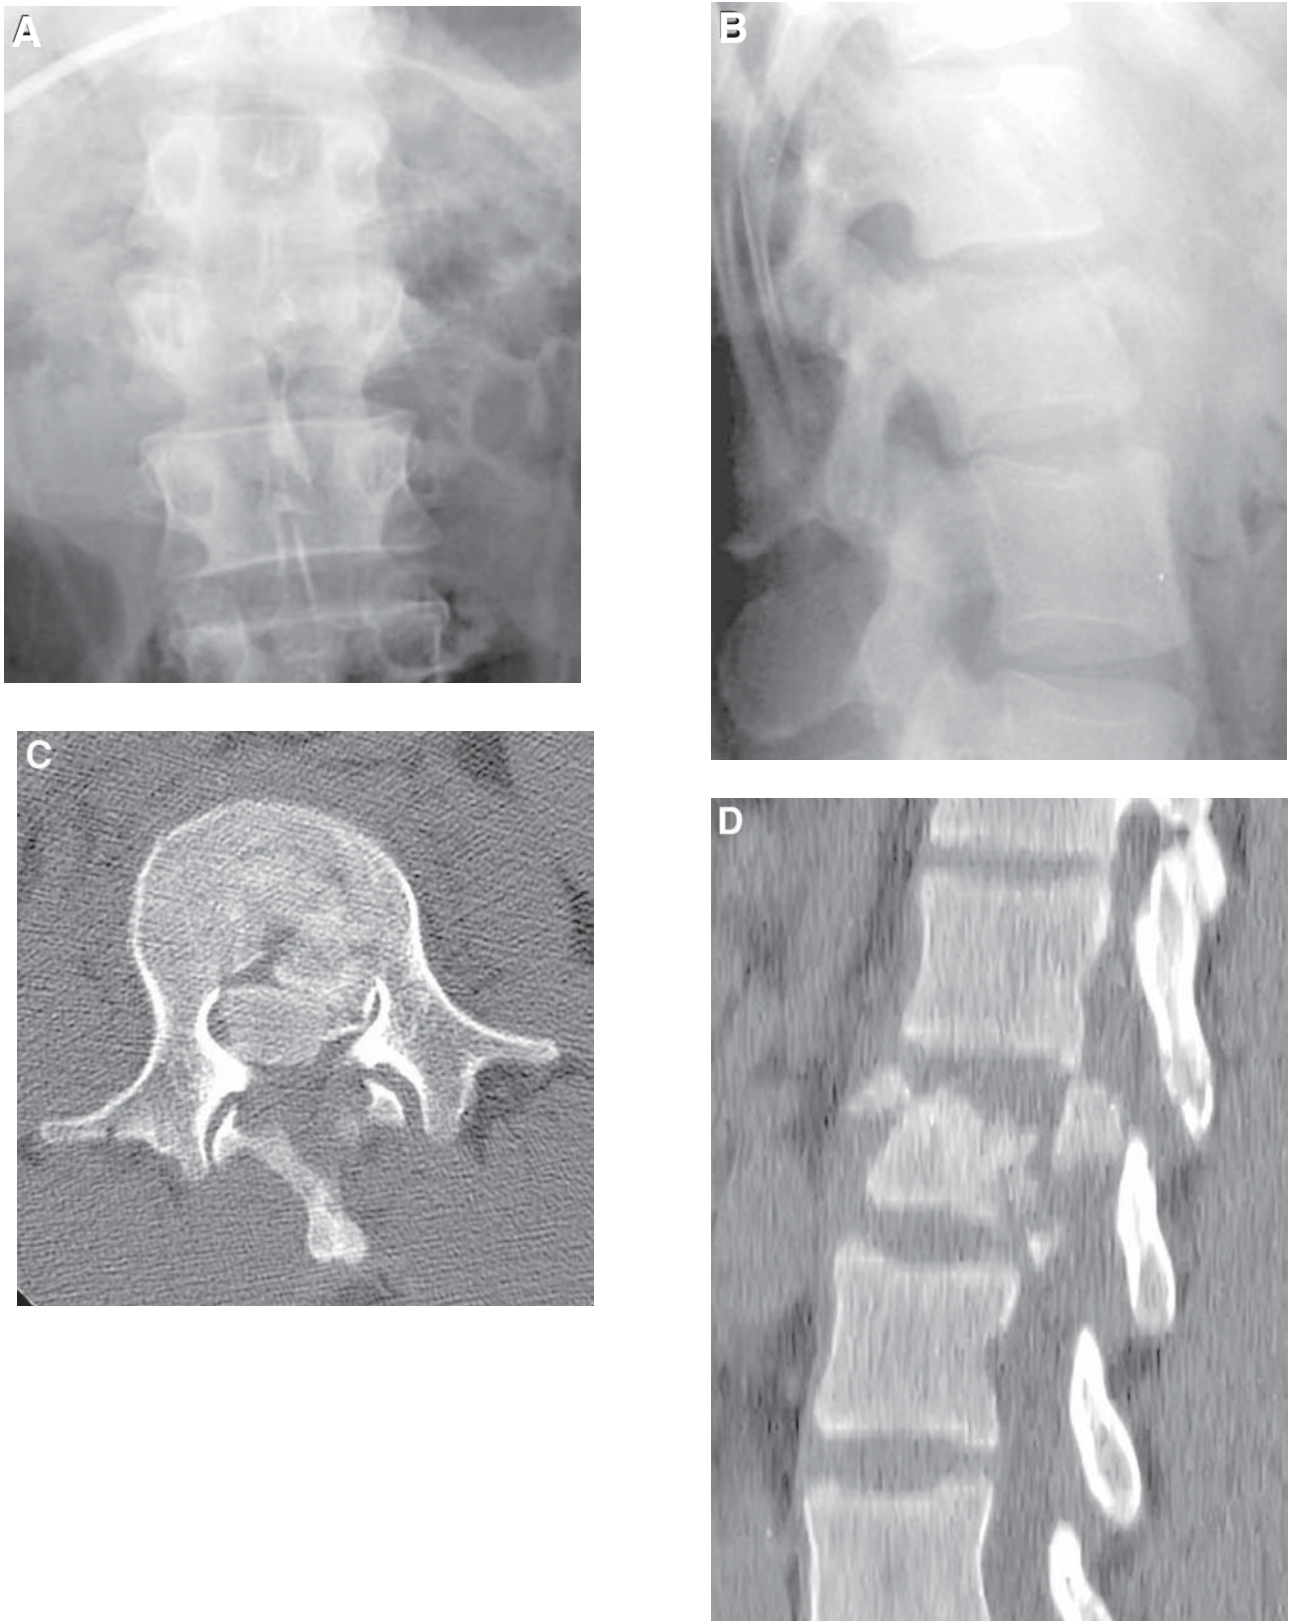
(A, B) AP and lateral radiographs demonstrate the classic findings of a burst fracture at the L2 level. There is vertebral collapse, retropulsion, and widening of the interpedicular distance. Axial CT (C) and sagittal CT reformation (D) show to better advantage the distribution of fracture fragments and the degree of retropulsion. (E) Sagittal STIR reveals ligamentous disruption posteriorly. Notice also edema
